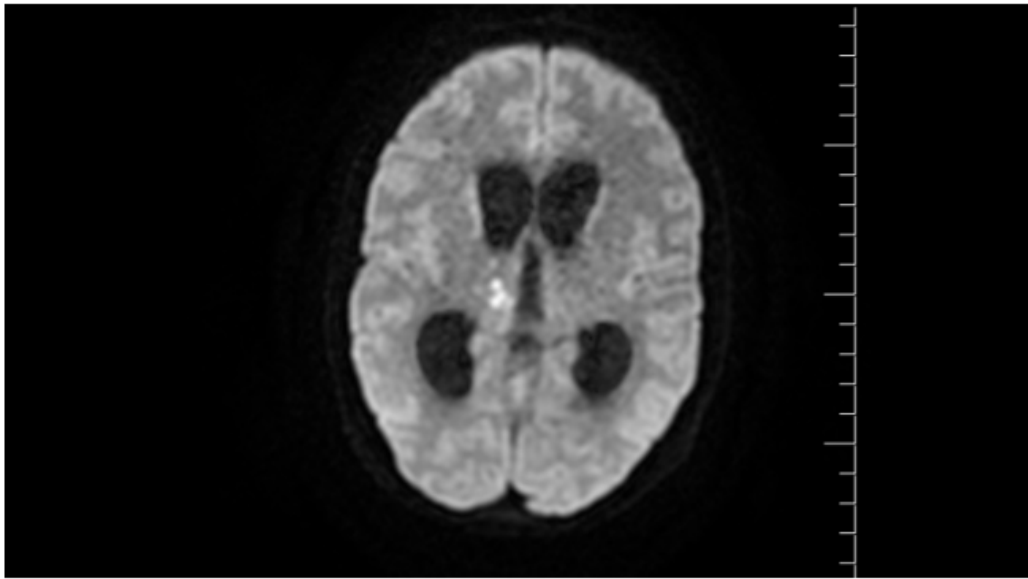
MRI Brain with severe hydrocephalus, RT thalamic infarction.
